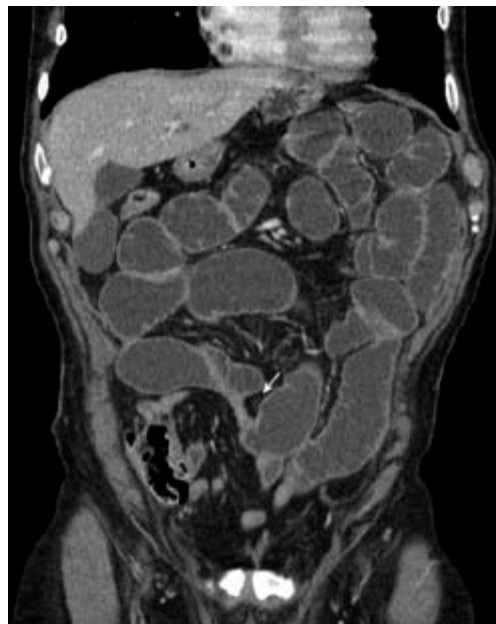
coronal reconstruction of an abdominal CT scan showing the "Fat notch sign" (white arrow) [64]
